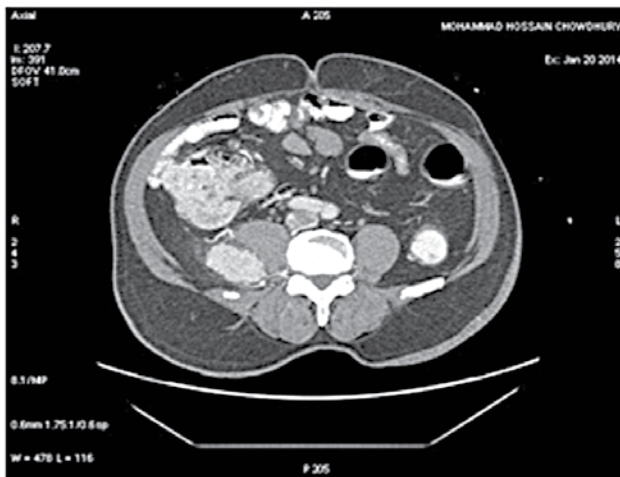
CT scan showing a mass behind right psoas muscle
